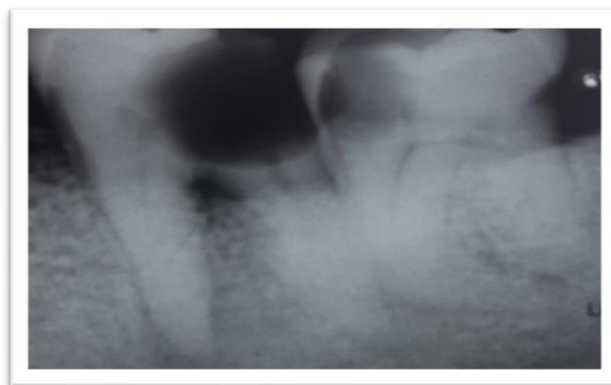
a: Preoperative radiograph.
